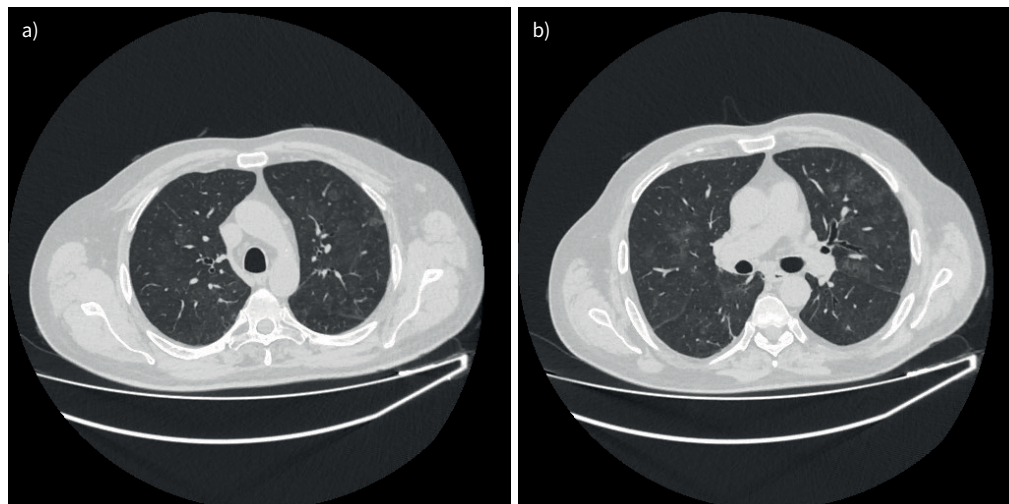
a, b) Chest computed tomography 6 months after mesalazine initiation and 1 month after the last dose of anti-TNF- α : limited emphysematous lesions, ground-glass opacities and mosaic attenuation.
